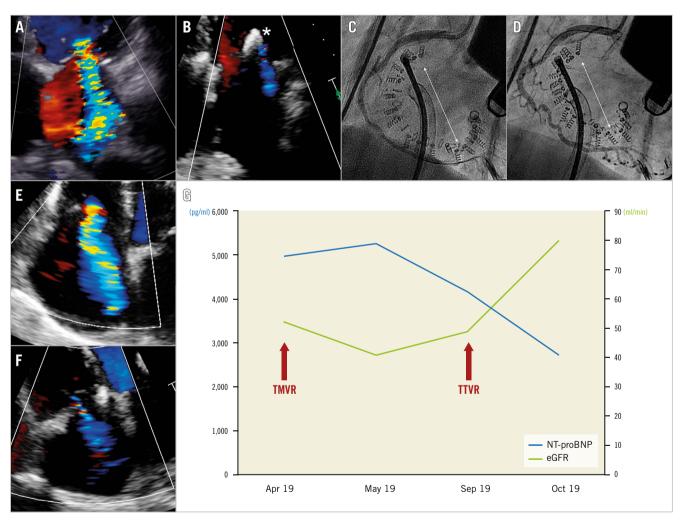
Transcatheter treatment of multivalvular disease. A) Baseline severe MR, transthoracic echocardiography. B) Result after implantation of one PASCAL device (asterisk) with mild residual MR. C) Transcatheter tricuspid direct annuloplasty with a Cardioband after placement of 17 screws before (2D diameter 4.1 cm) and (D) after (2D diameter 3.2 cm) cinching of the annulus (arrow: approximate annular diameter). E) Baseline TR, transthoracic echocardiography. F) Result after annuloplasty with residual TR grade 1+. G) Evolution of NT-proBNP (pg/ml) and eGFR (ml/min) at the time of transcatheter mitral valve repair (TMVR), follow-up, transcatheter tricuspid valve repair (TTVR) and 30 days after both procedures.
